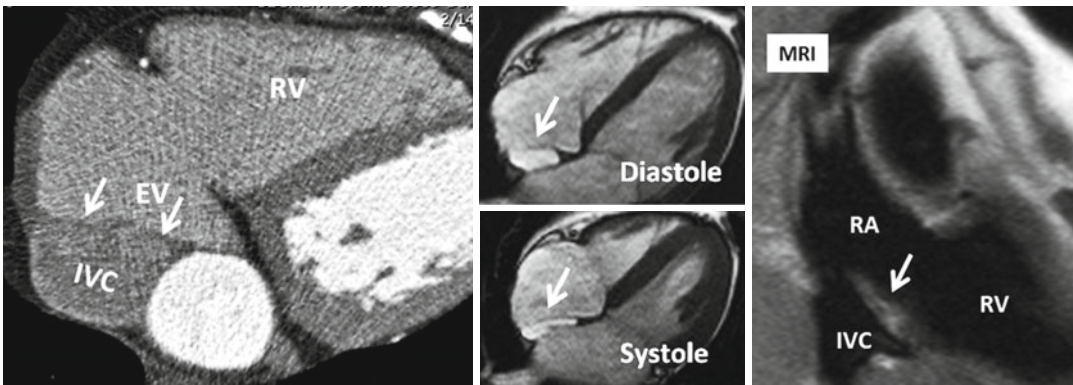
Prominent Eustachian valve (*EV*) shown on axial CT and MR images (*arrows*). The EV guards the anterior-inferior aspect of the inferior vena cava (*IVC*).
